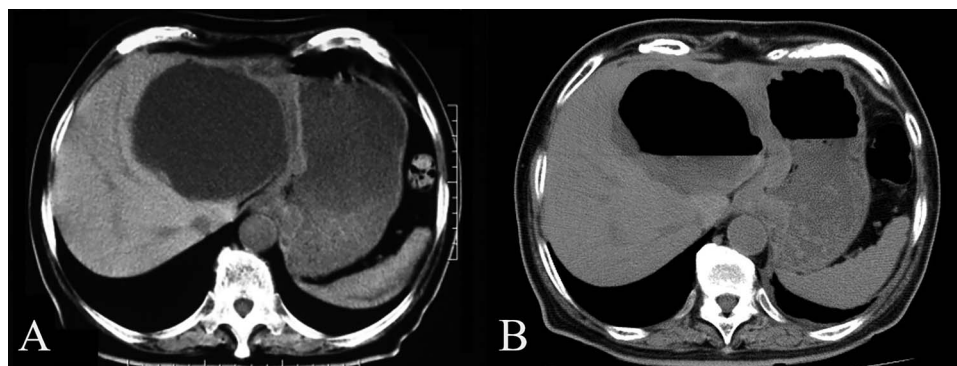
Abdominal CT pre- (A) and post-endoscopy (B). (A) Abdominal CT reveals the presence of a giant cyst, 10 cm in size, in the left hepatic lobe. (B) Abdominal CT following endoscopy reveals an air-fluid level in the liver cyst, most likely caused by the forced air administered during endoscopy.
